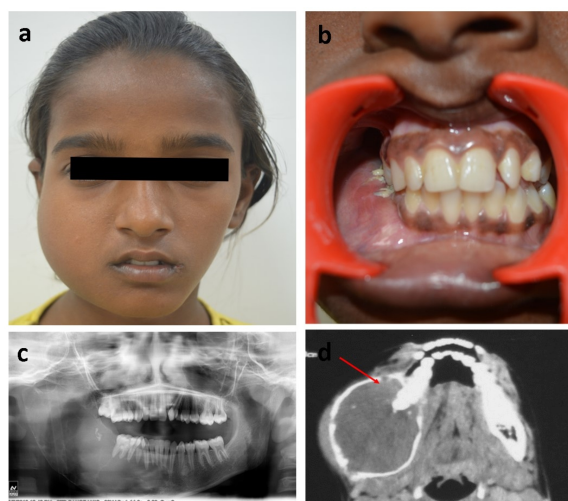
Preoperative clinical and radiographic presentation. a. Swelling in the right-side of face; b. Expansion and obliteration of lower buccal vestibule; c. OPG showing multi-locular radiolucent lesion involving entire right-side of mandible; d. CT axial section showing expansive lesion with cystic-solid component (arrow indicates solid component)
